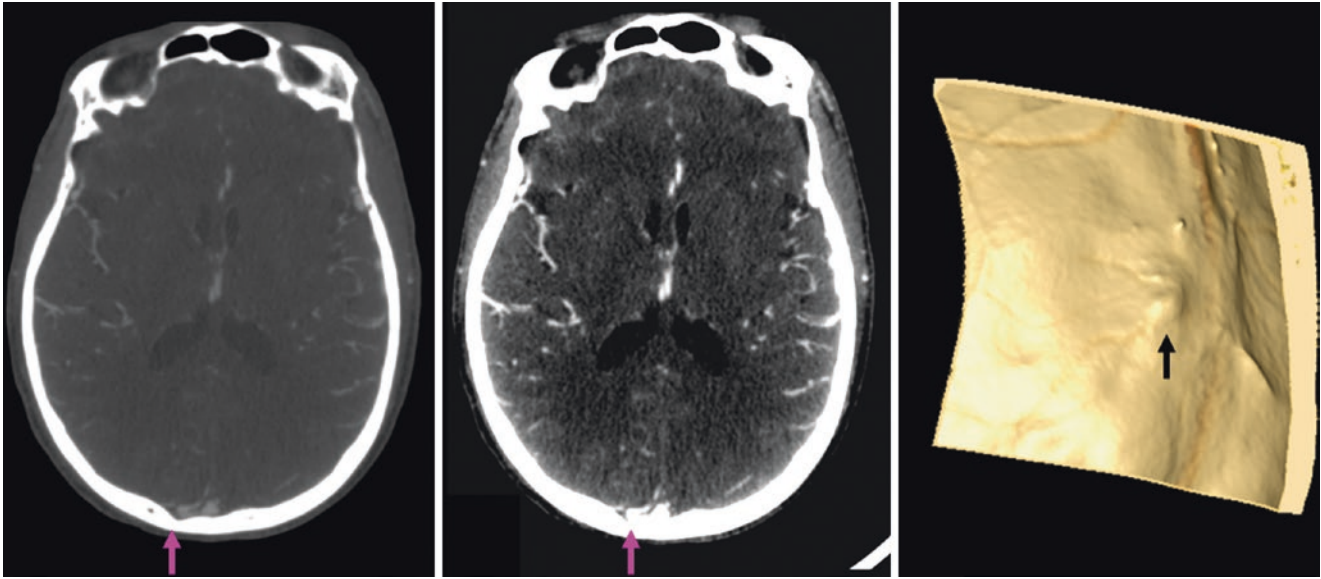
A 58 year old in whom a cortical vein connecting to the superior sagittal sinus is contained within a calvarial depression on postcontrast source CTA images (*left and middle*). Three-dimensional
